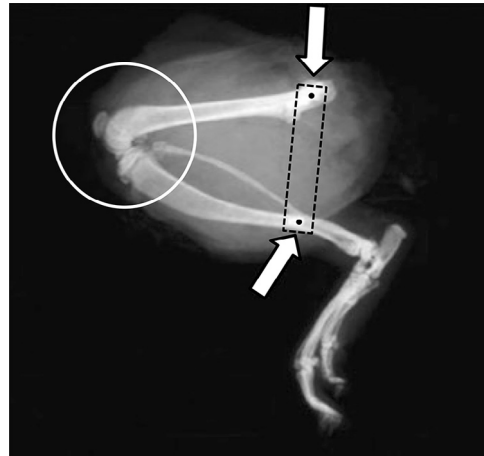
X-Ray image of a knee joint after immobilization. The knee joints were immobilized with an internal, but extra-articular, fixator at  $150^\circ$  of flexion. A rigid plastic plate implanted subcutaneously fixed the proximal femur and distal tibia away from the knee joint and was solidly held in place with one metal screw at each end. The knee joint capsule and the joint itself were untouched. Arrows indicate the positions of the metal screws. The broken line indicates the position of the plastic plate. The circle indicates the position of the probe of low-intensity pulsed ultrasound.
